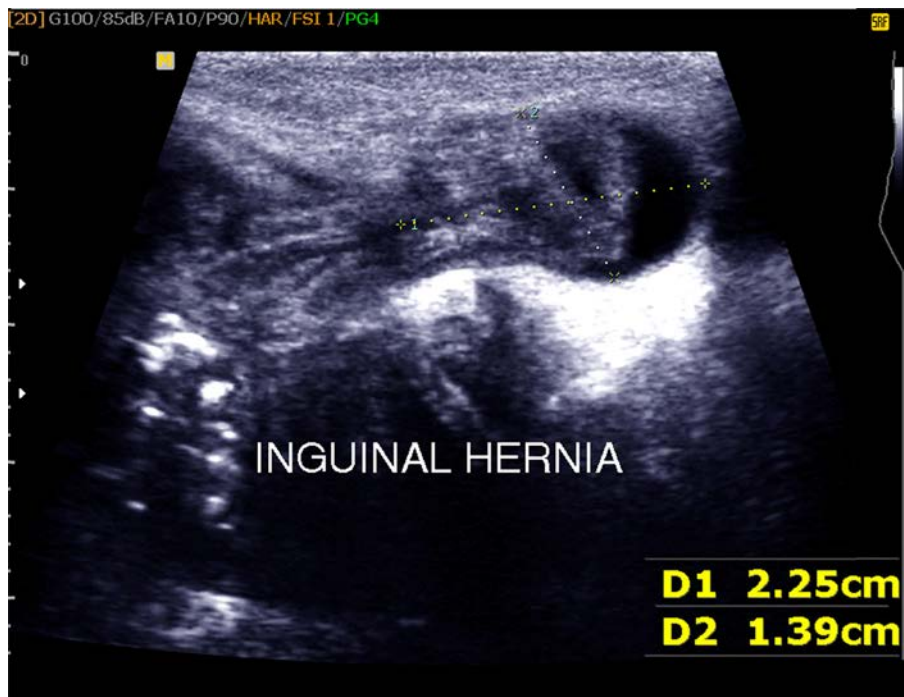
Ultrasonography exam showing hernia sac in the inguinal region with omentum and fluid inside.
